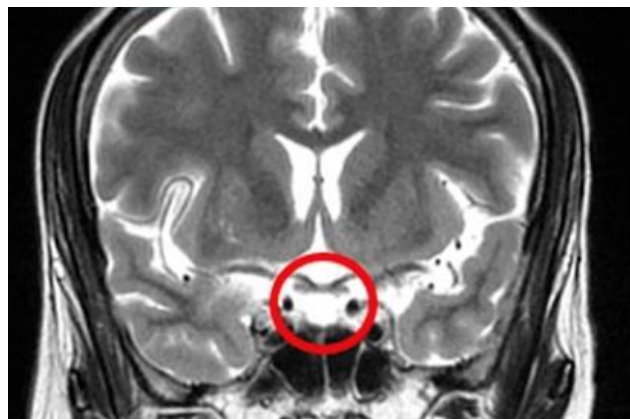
Coronal T2-weighted MRI demonstrating a fluid-filled sella turcica (CSF signal intensity) with a flattened pituitary gland along the sellar floor
